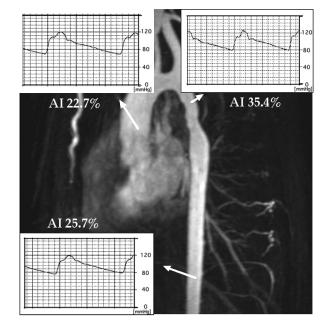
Magnetic resonance imaging and pressure waveforms of aorta after balloon angioplasty treatment. In normal aorta, the augmentation index (AI) increases when the pressure sensor gets closer to the aortic bifurcation, which is a major reflection point. However, AI in the descending aorta was just lower than that in the aortic arch, which means that there was a strong reflection wave from the extended portion. Pressure waveforms recorded with a pressure sensor mounted catheter (Millar, SPC-464D; Millar Instruments).
